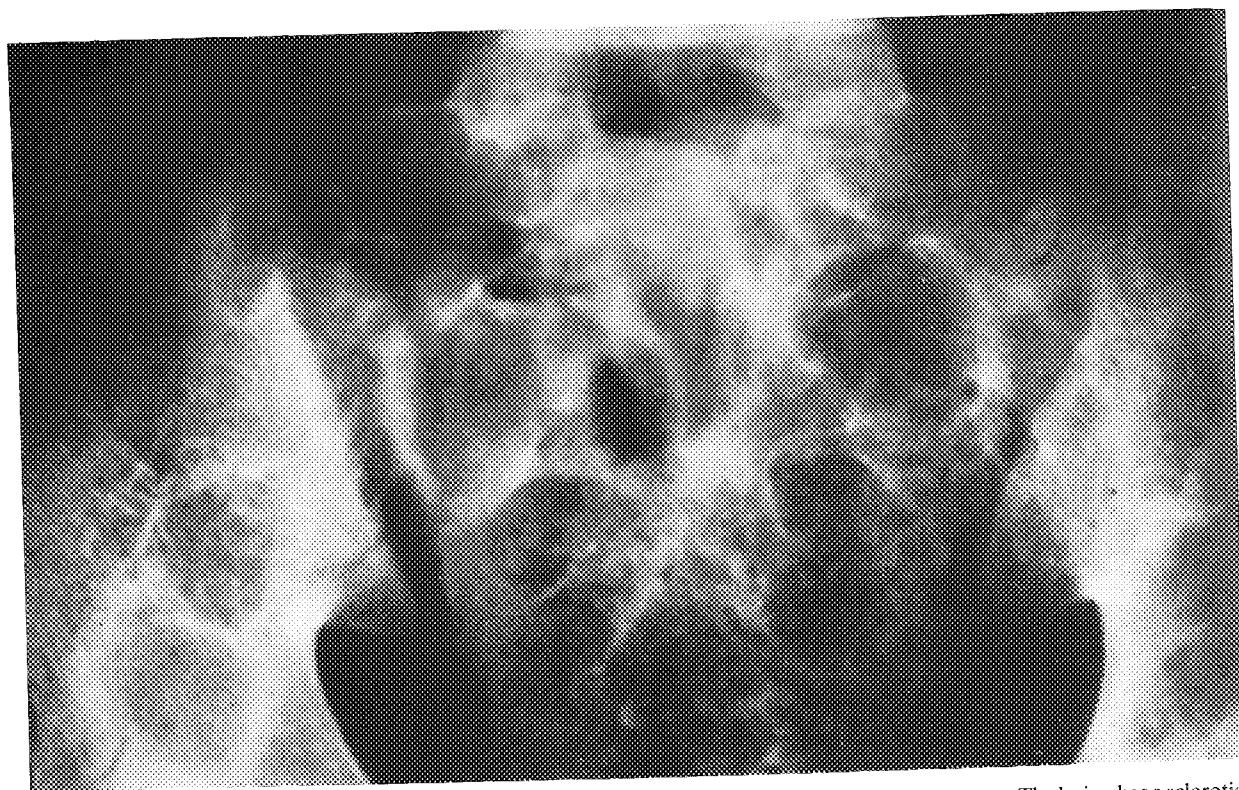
Frontal radiograph of the sacrum which shows expansion of the right lateral mass of the first sacral segment. The lesion has a sclerotic rim and lucent centre.
